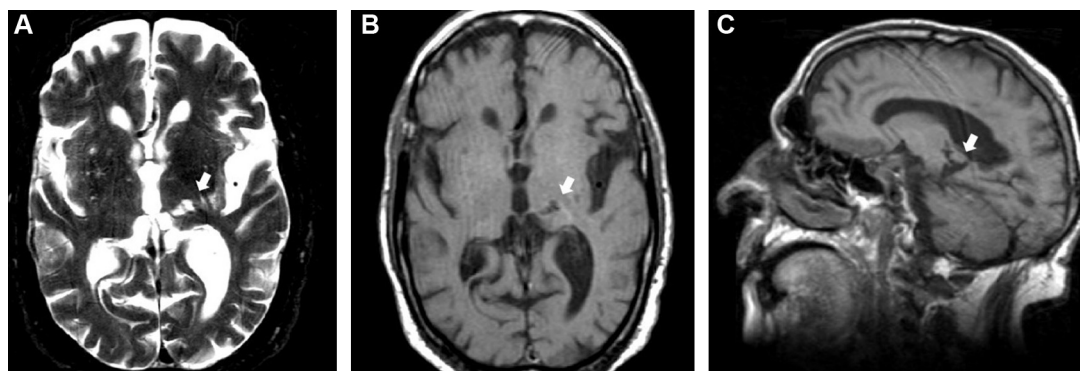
Axial (A) T2-weighted and (B) T1-weighted MRI showing an old ischemic lesion in the posterolateral thalamus (arrow). (C) Sagittal T1-weighted MRI demonstrating the same lesion (arrow) and an enlarged lateral ventricle.
